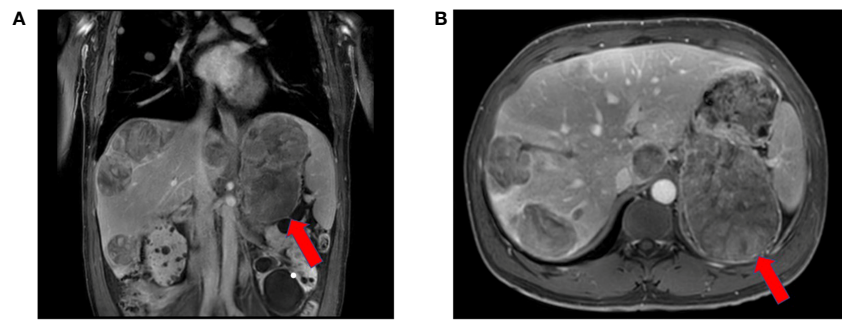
Red arrowheads indicate the primary tumor at diagnosis. Contrast-enhanced magnetic resonance imaging revealed a 158 mm x 112 mm heterogeneously enhanced left suprarenal mass with necrosis.
